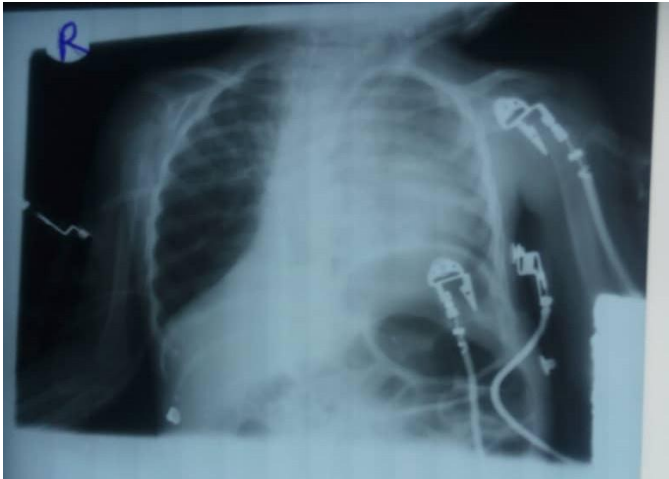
Radiograph showing atelectasis of the left lung
